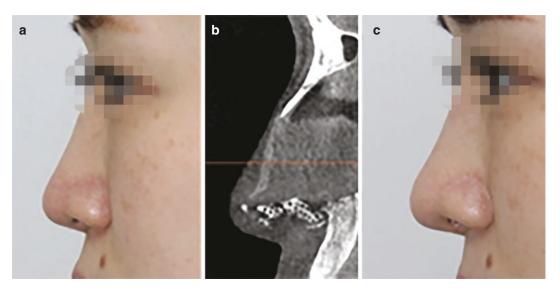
Iatrogenic hump was shown after rhinoplasty using goretex implant. (a) Preoperative view, (b) preoperative CT scan, and (c) postoperative view with autologous tissue
